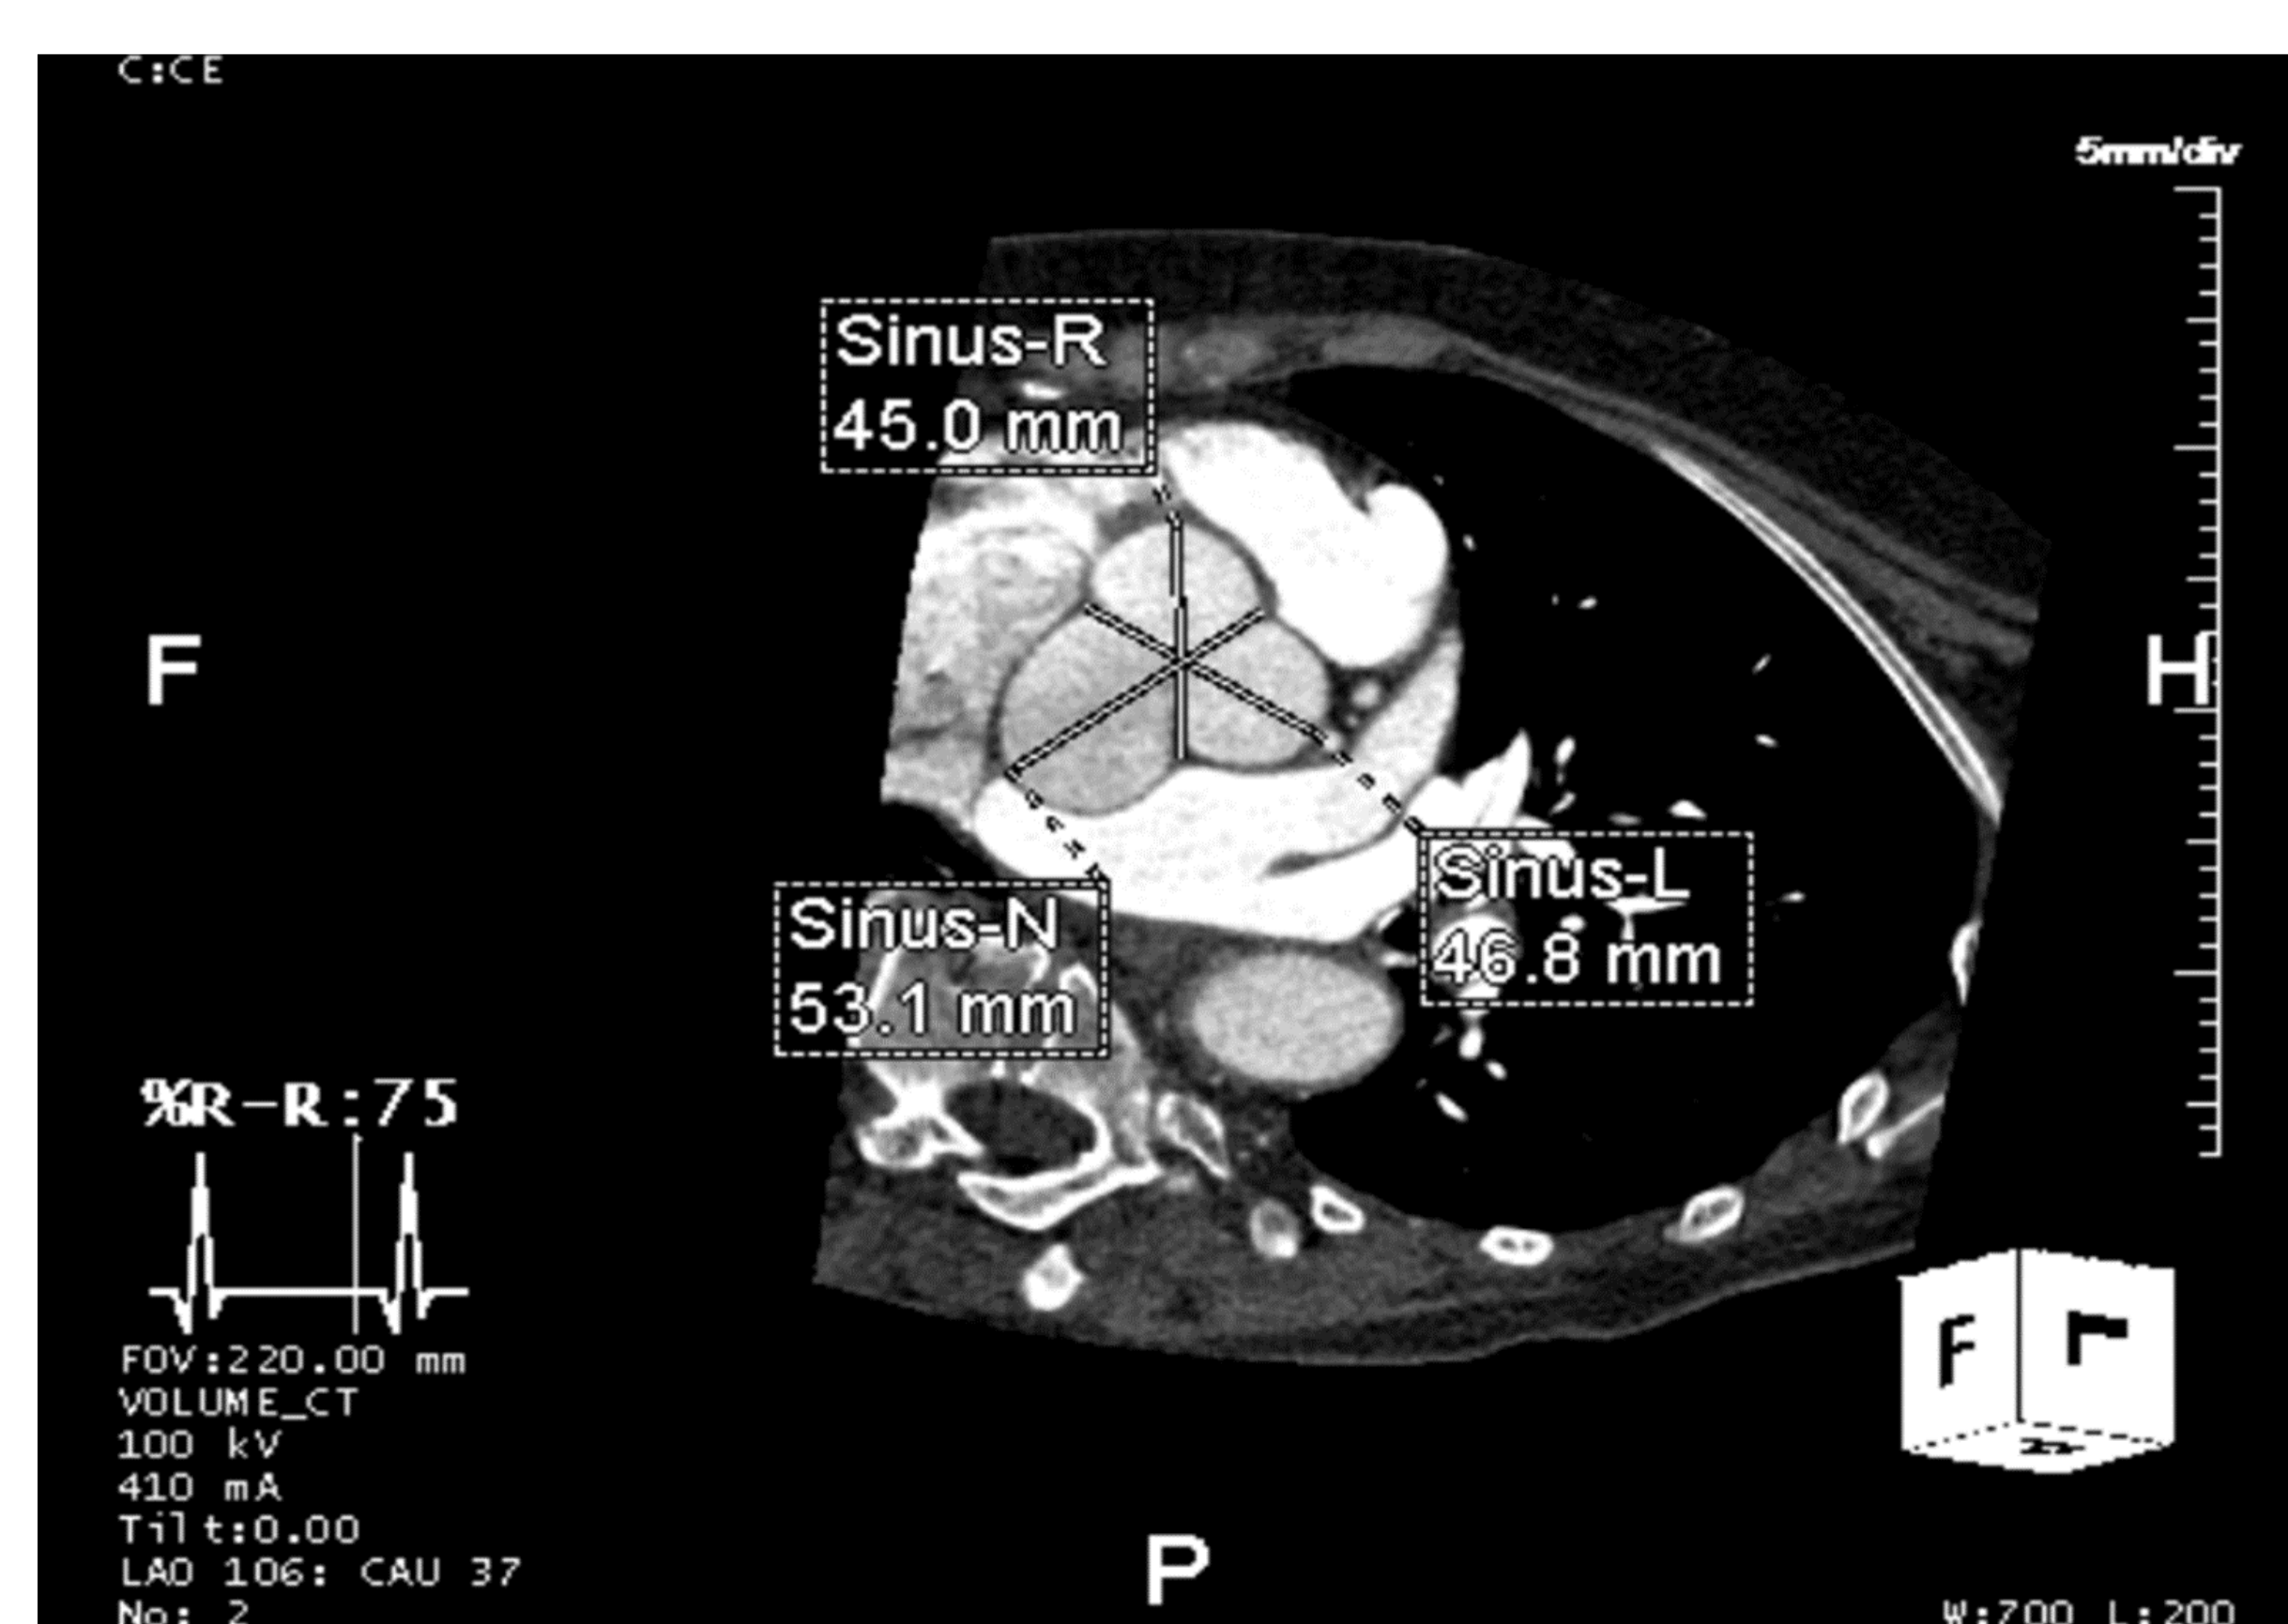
CT Aortogram of the aortic root (mid sinus to mid sinus) calibre of 5.3cm
